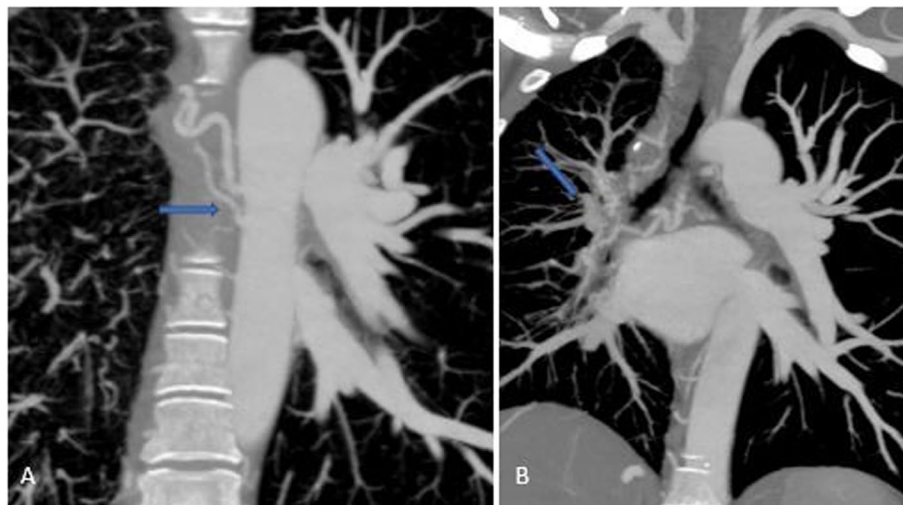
CT Angiography MIP images coronal view (A, B) showing dilated and tortuous right bronchial arteries arising from the aorta (marked by the blue arrow)
